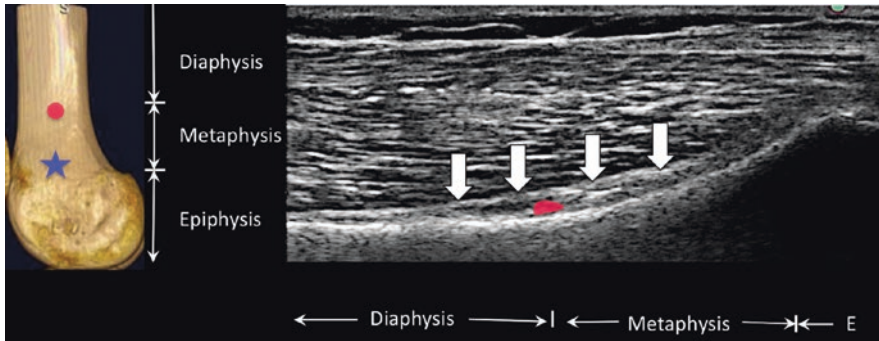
The left panel showed the target for the fluoroscopy-guided injection (star). However, the ultrasound showed the fascia expansion (bold arrows) and the vessel at a more proximal location (red dot in the left panel). The red spot in the right panel is not a sign of Doppler but was artificially added to show the vessel, which was seen in the video. E, epiphysis. (Reprinted with permission from Philip Peng Educational Series)
